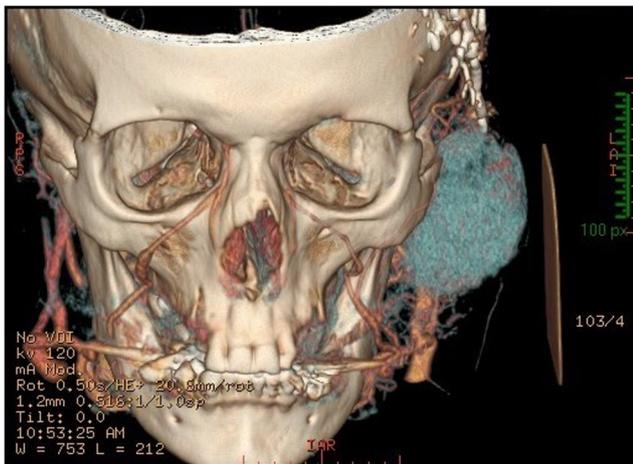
Postoperative CT-three-dimensional reconstruction showing nodal metastasis into parotid gland
